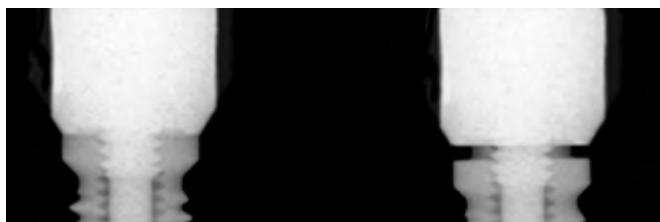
This radiograph demonstrates the differences between complete seating of a healing abutment (left) and incomplete seating of a healing abutment (right) onto implant restorative platforms.
